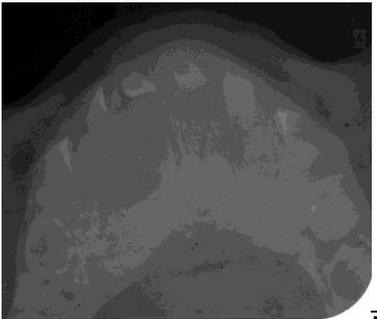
Radiograph showing mandibular expansion with ill-defined opacification and ground glass appearance.
